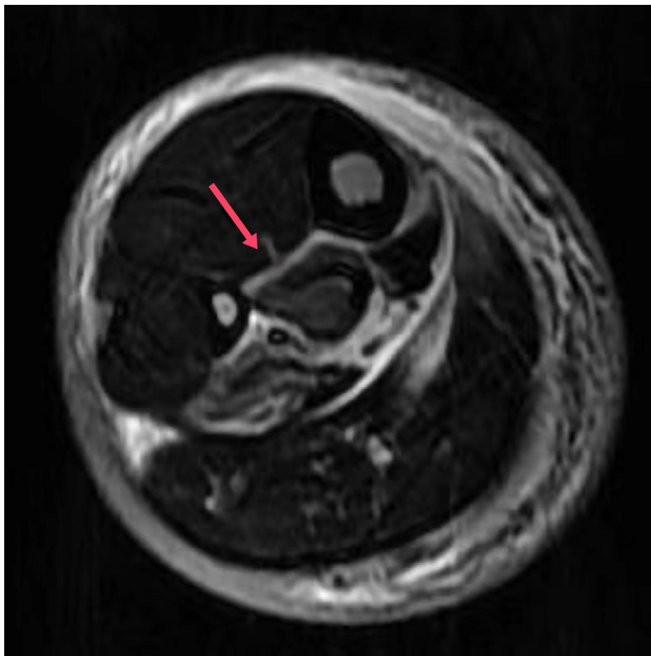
The axial MRI (cross-sectional FS T2WI images) of the middle calf showing the intact interosseous membrane (red arrow: intact interosseous membrane)
